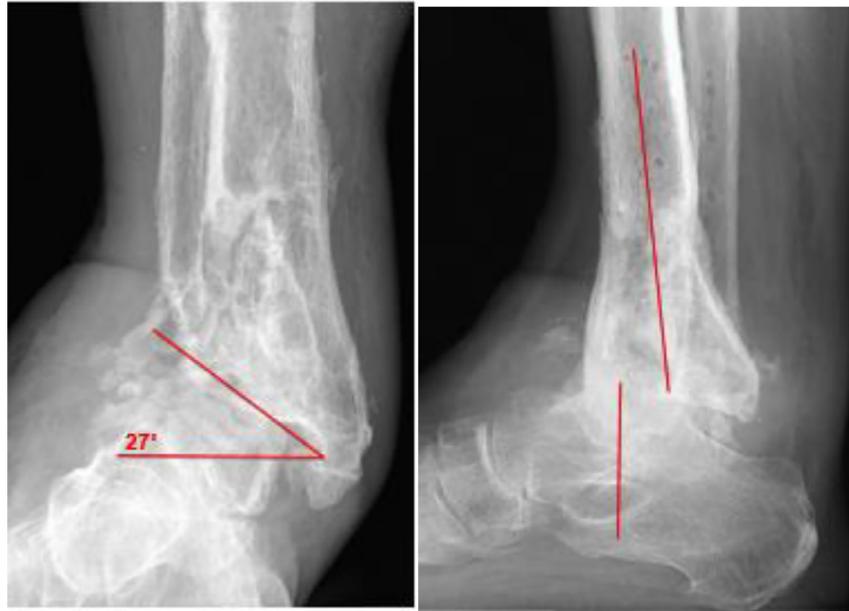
Preoperative anteroposterior and lateral ankle radiographs displaying severe valgus deformity and anterior ankle subluxation.
